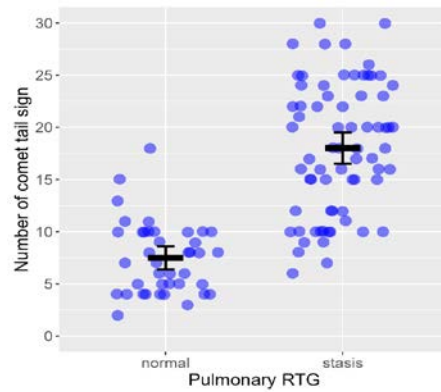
Radiography finding shows a bigger average number of ultrasound lung “comets” in relation to pulmonary stasis. RTG–X-ray.
